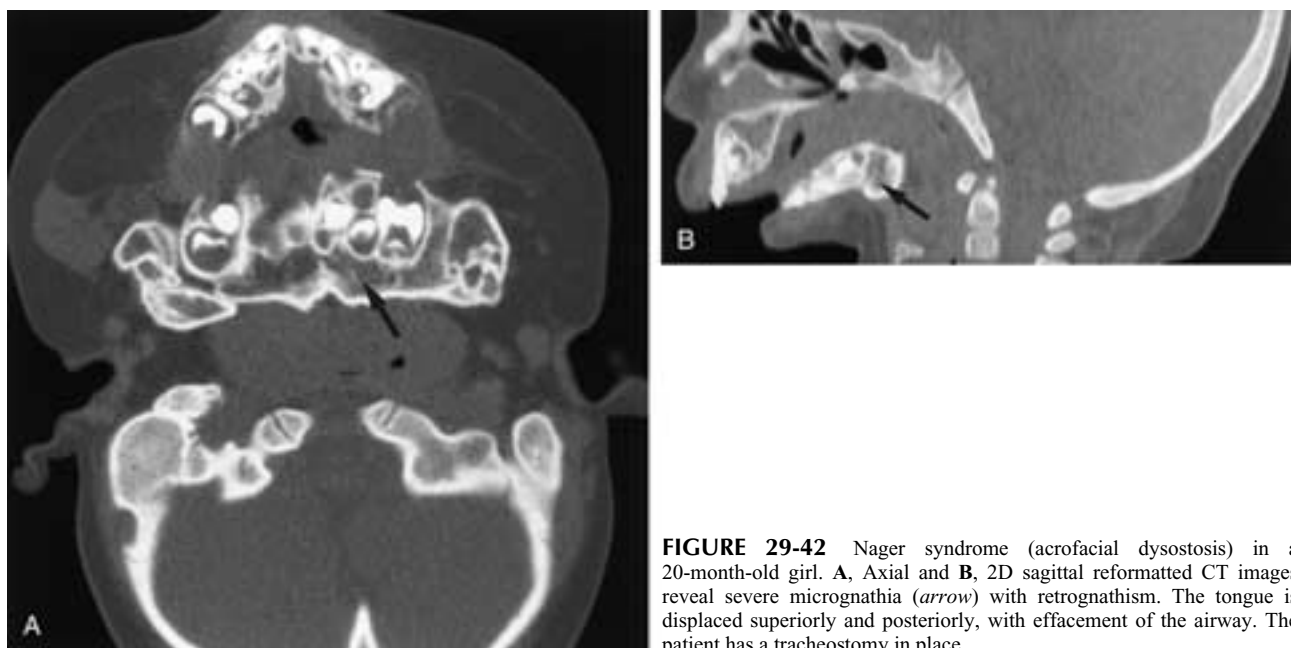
Nager syndrome (acrofacial dysostosis) in a 20-month-old girl. A, Axial and B, 2D sagittal reformatted CT images reveal severe micrognathia (*arrow*) with retrognathism. The tongue is displaced superiorly and posteriorly, with effacement of the airway. The patient has a tracheostomy in place.
